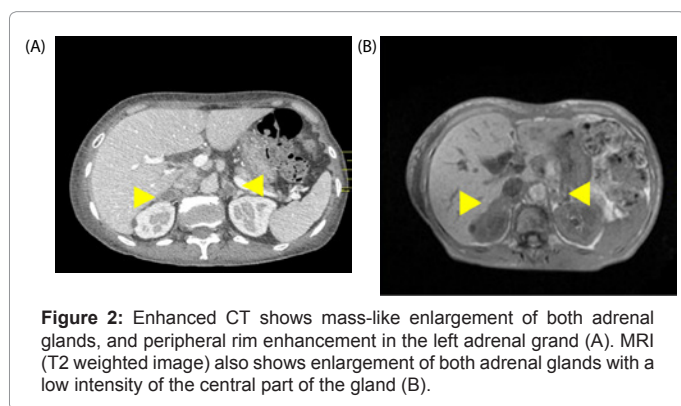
Enhanced CT shows mass-like enlargement of both adrenal glands, and peripheral rim enhancement in the left adrenal gland (A). MRI (T2 weighted image) also shows enlargement of both adrenal glands with a low intensity of the central part of the gland (B).
